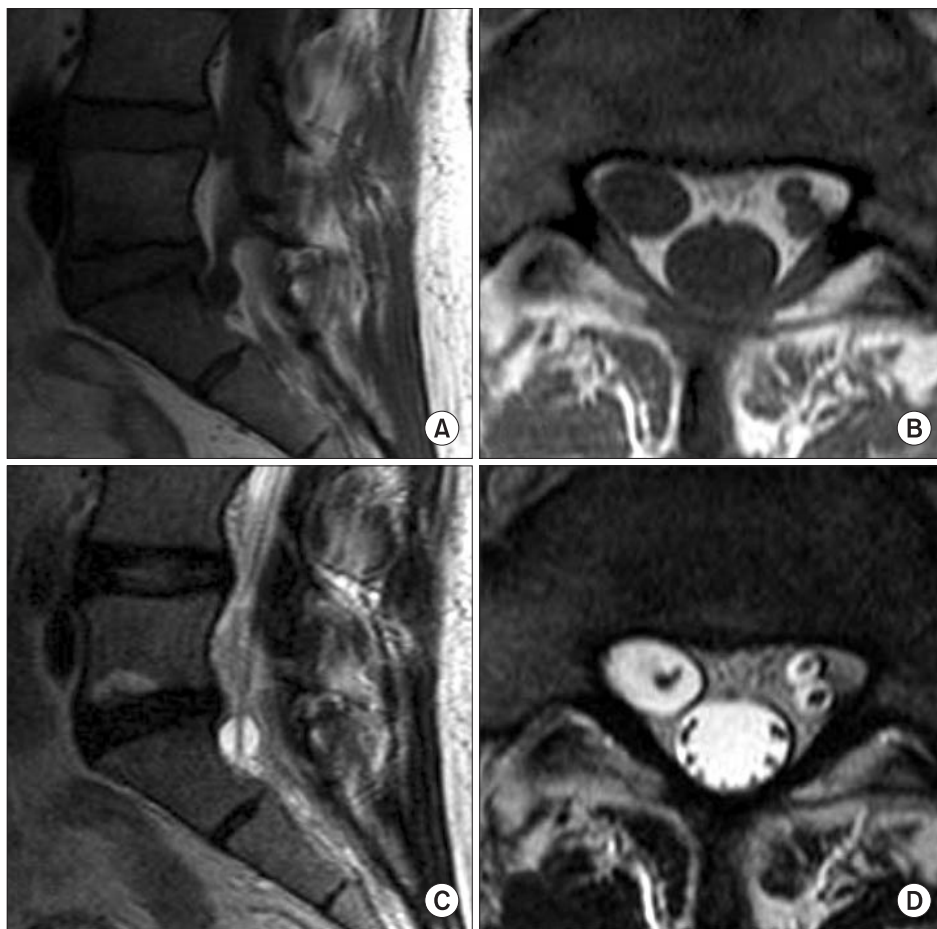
The MRI of lumbosacral region demonstrates a cystic area in the right spinal canal at L5 and S1 intervertebral disc level. It appears hypointense on T1-weighted image (A, B), and hyperintense on T2-weighted image (C, D).
